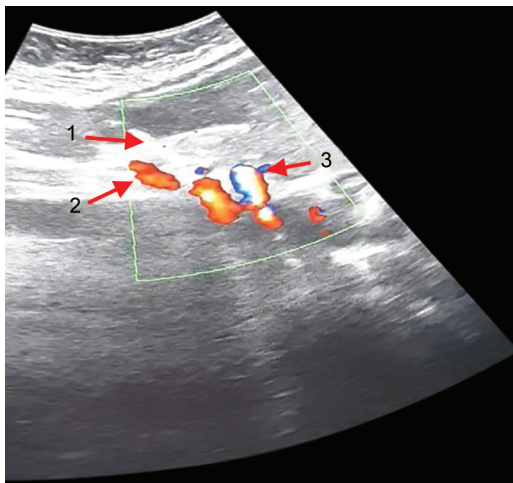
Under ultrasonography long axis the needle (the entire length of needle shown) advances until a typical pattern appears “Trident”, i.e., needle shown by arrow between (1) two vessels superior mesenteric artery shown by arrow (2) and CT shown by arrow (3)
